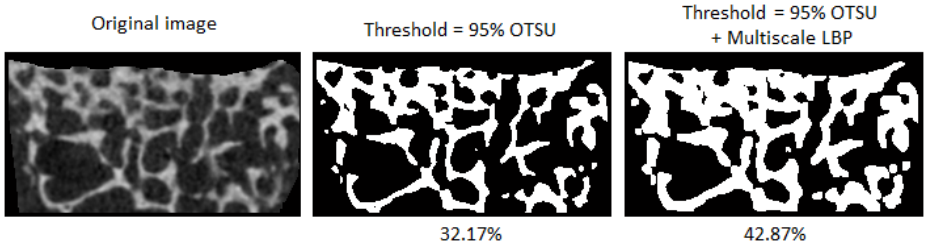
Comparison between different methods to select the relevant pixels within an original μ CT scan. The percentage represents the amount of selected pixels within the segmented area of the original image. Using Otsu thresholding alone gives an initial estimation for the bone pixels. Combination of Otsu thresholding and multiscale LBP selects both bone areas and the relevant surrounding pixels, and it is considered to better select relevant pixels in the analysis
